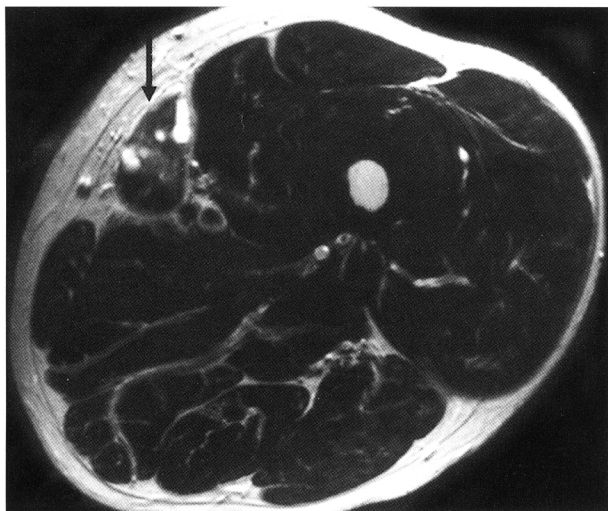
MRI findings show multiple elongated tubular tract of heterogeneous high signal intensity on T2-weighted images (arrow) in the sartorius muscle on T2-weighted axial image.
